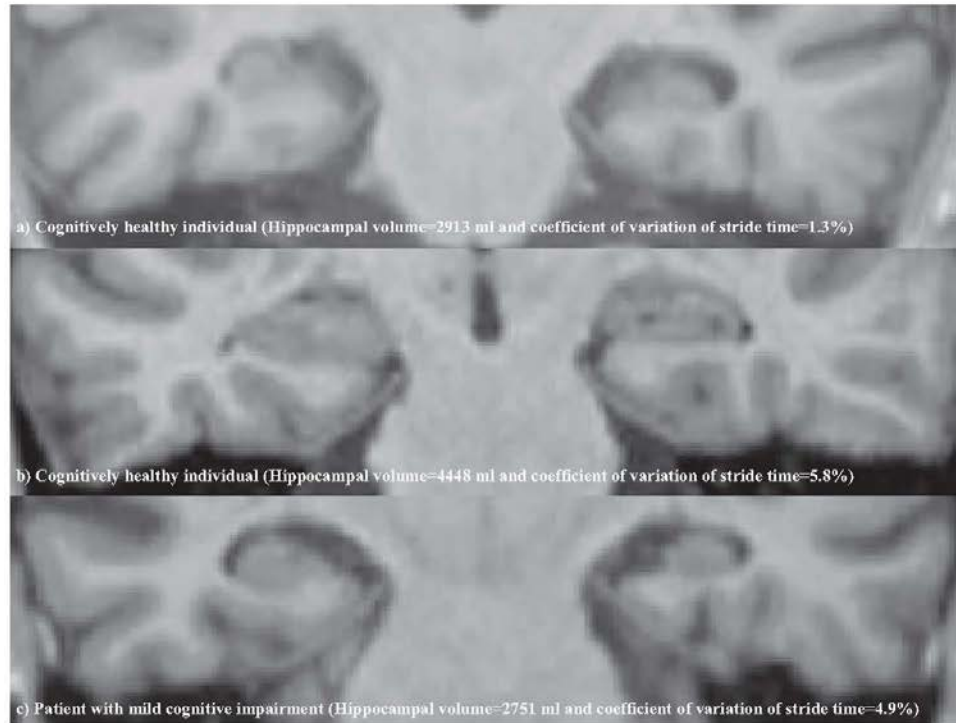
Coronal T1-weighted MRI images of hippocampus of three characteristic participants (two cognitively healthy individuals a) and b), and one patient with mild cognitive impairment c)).
